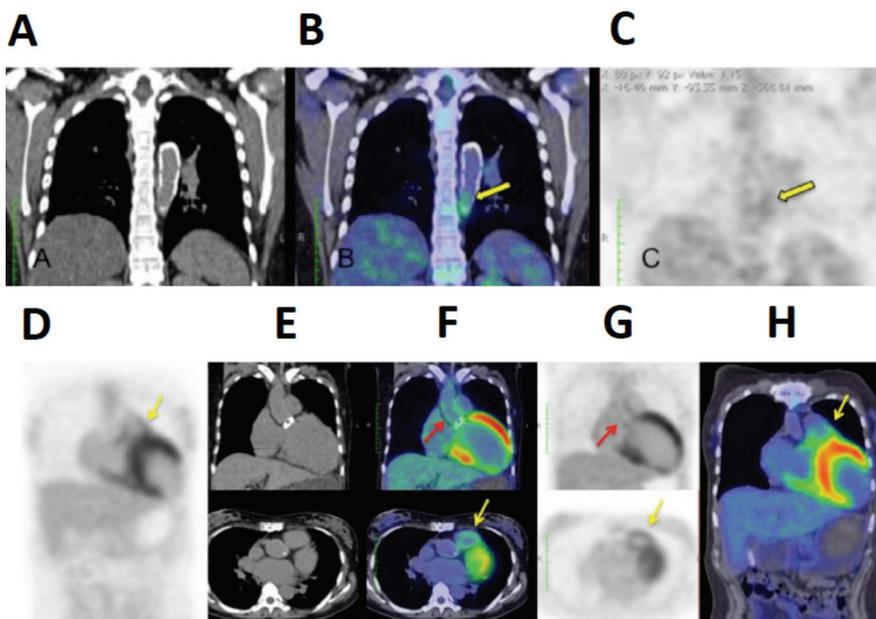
Images from a 32-year-old female patient with long evolution TAK presenting calcification of the wall: Coronal projection of simple phase CT (A), fusion (B) and PET ^{18}F -FDG (C), all consistent with active disease in the descending thoracic aorta (yellow arrow). Images from a 36-year-old woman with Numano V TA with local ^{18}F -FDG capture in the aortic root (D), ascending aorta (red arrows F and G panels) as well as the pulmonary torso (yellow arrows) in panels D, lower G and H compatible with active disease.
